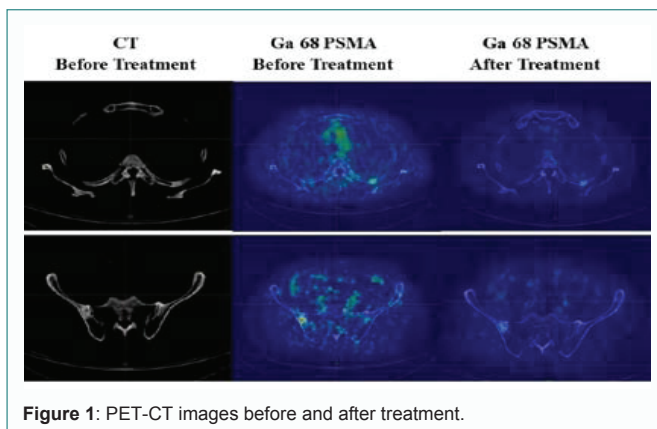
PET-CT images before and after treatment.
